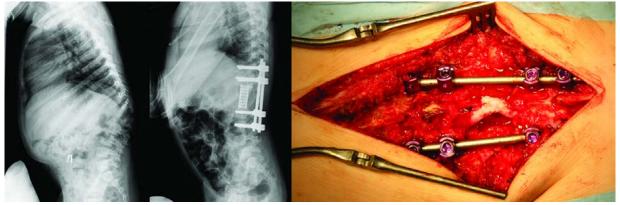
Patient, 4 years and 8 months old (case 3), with SSD at the level of the thoracolumbar junction: lateral radiographs before and after the operation; intraoperative photo shows the site of the narrowed dural sac, the dura mater is rigid
